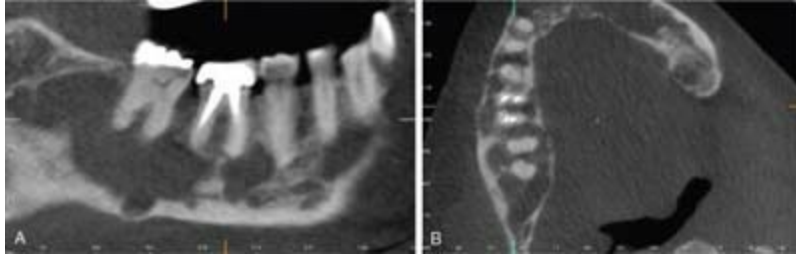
Hyperparathyroidism. A, Sagittal CBCT image with multiple low-density lesions and changes in mandibular bone density. B, Axial CBCT image showing a thinning of the cortical plates in association with the low-density lesions.
